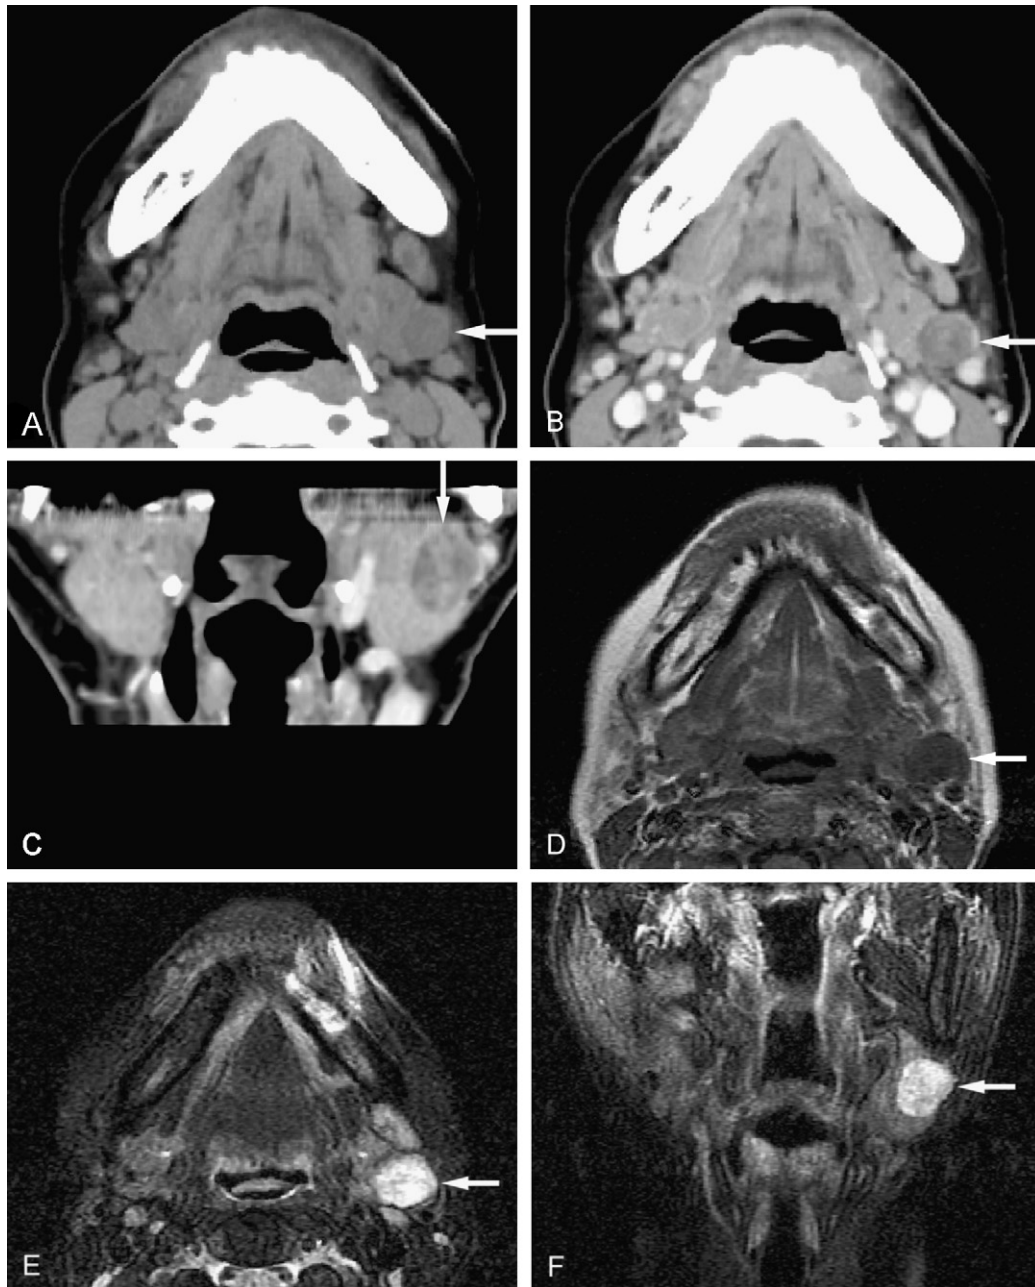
Pleomorphic adenoma of the submandibular gland in a 55-year-old female. A well-defined margin and smooth border tumor (arrows) can be detected on the CT and MR images. (A) The tumor shows a homogeneous intermediate signal intensity on a plain CT image. (B) After contrast medium administration the tumor shows a low signal intensity and an inhomogeneous enhancement on an axial CE CT image. (C) The tumor shows a low signal intensity on a coronal reformatted CE CT image. (D) The axial T1-weighted MR image shows an intermediate signal intensity mass. (E) On an axial T2-weighted MR image using the FS technique, the tumor shows an inhomogeneous high signal intensity mass. (F) The tumor shows a lobulated border and inhomogeneous high signal intensity on a coronal T2-weighted MR image using the FS technique.
